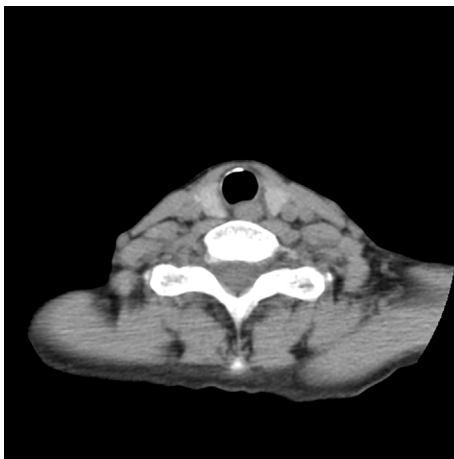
Contrast-enhanced computed tomography did not show any abnormalities around the cervical esophagus.
